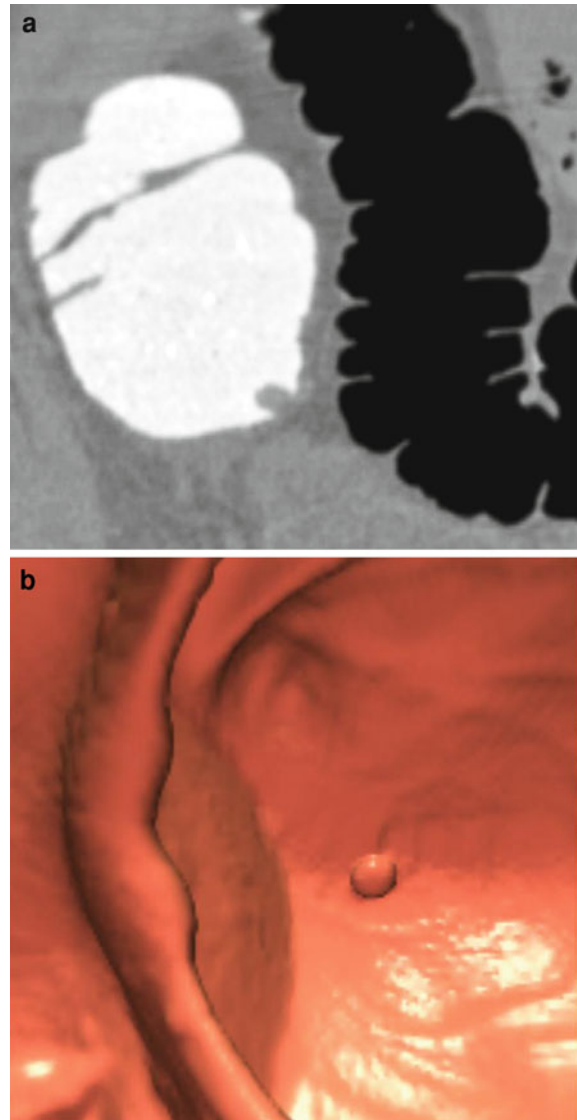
Inverted appendiceal stump. 2D coronal (a) and 3D endoluminal (b) images from CT colonography screening show a polypoid cecal lesion at the expected location of the appendiceal orifice, which represents an inverted appendiceal stump
